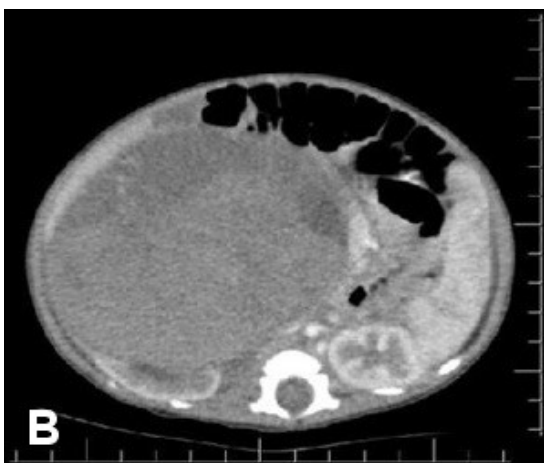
CT scan suggesting renal tumor.
